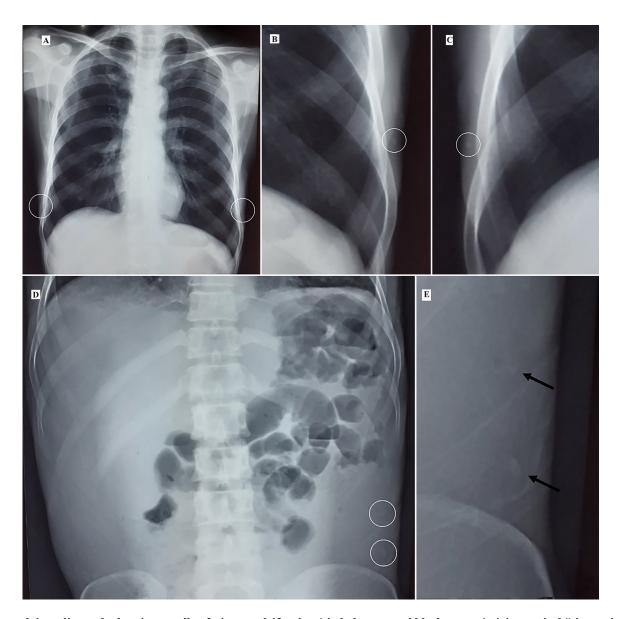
Plain radiograph showing small soft tissue calcification (circled areas and black arrows) giving typical "rice grain appearance". (A) In bilateral chest wall of chest radiograph. (B and C) Magnified view of the chest radiograph. (D) In left lateral abdominal wall of erect abdominal radiograph. (E) Magnified view of the abdominal radiograph.
